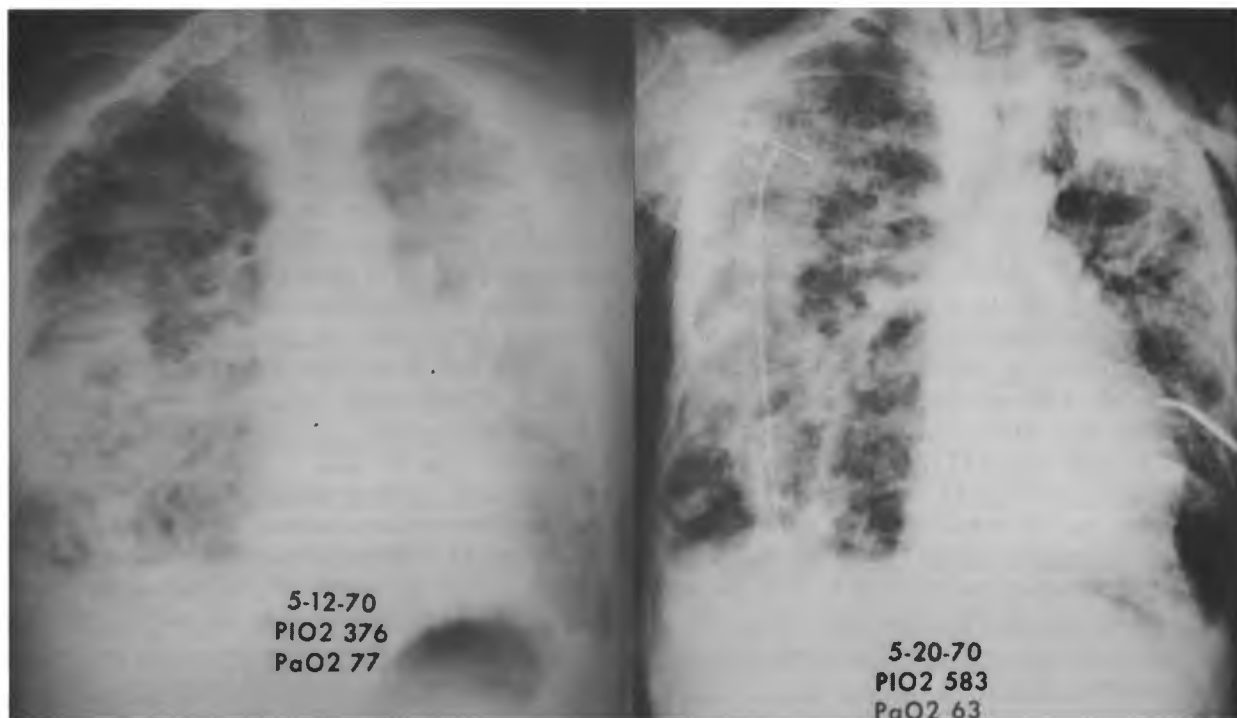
(left)—Massive bilateral pulmonary infiltrations on admission with severe impairment in oxygen transport (P_{iO_2} , 376; P_{aO_2} , 77) (Case 3). Fig. 8 (right)—Terminal chest x-ray film shows diffuse pulmonary fibrosis and evidence of right-sided pneumothorax and tube placement.
